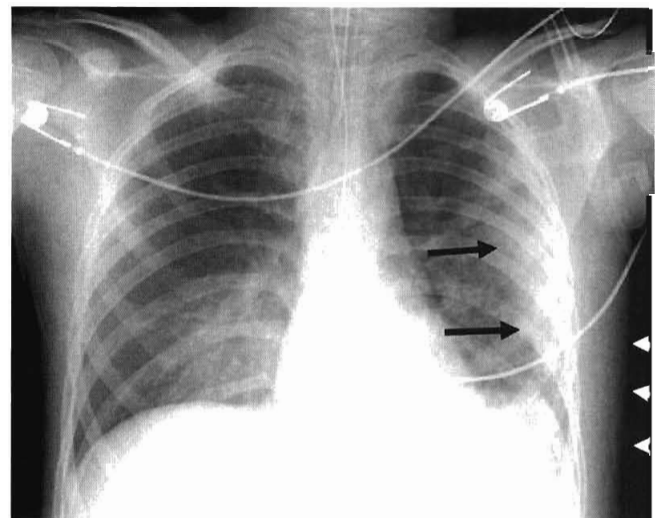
A 12-year-old boy presented with injuries sustained in a motor vehicle accident. Chest radiograph shows peripheral pulmonary contusion (*arrows*). Swelling of the soft tissue of the left chest wall adjacent to the area of pulmonary contusion is noted (*arrowheads*).
